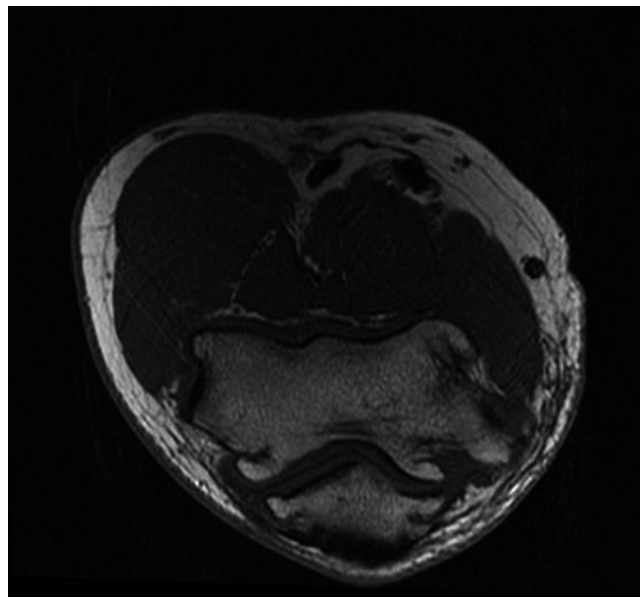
Axial T1 MRI image demonstrating osteophytes along the articulation of the olecranon posteriorly and the olecranon fossa more anterior
